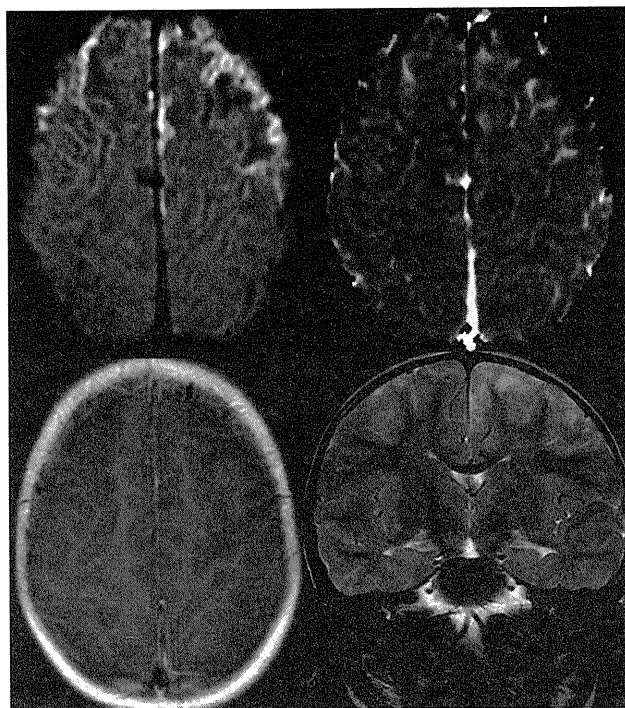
MRI at 18 months. (A) Axial diffusion-weighted image; (B) Axial ADC map; (C) Contrast-enhanced axial T1-weighted image; (D) Coronal T2-weighted image. There is restricted diffusion at level of the frontal cortex bilaterally (A, B) consistent with cytotoxic edema. The blood-brain barrier is intact (C) although the cortex is swollen (C, D).
